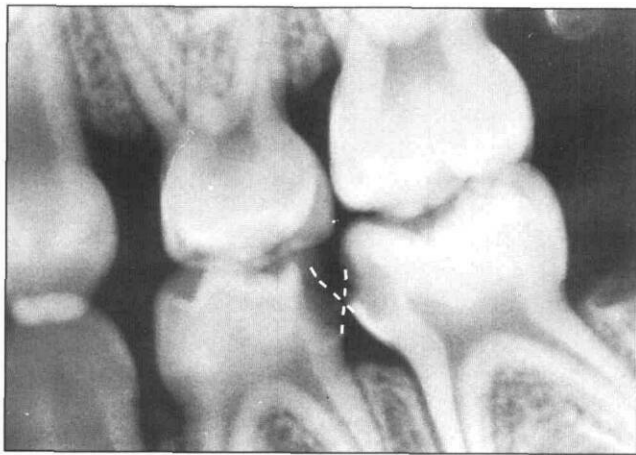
Radiograph in which extensive proximal caries, contact loss, and mesial drift are evident. Mesial drift is revealed by the overlapping of the dotted lines which replace the missing proximal surfaces. The alveolar bone between the primary molars appears to be normal.
